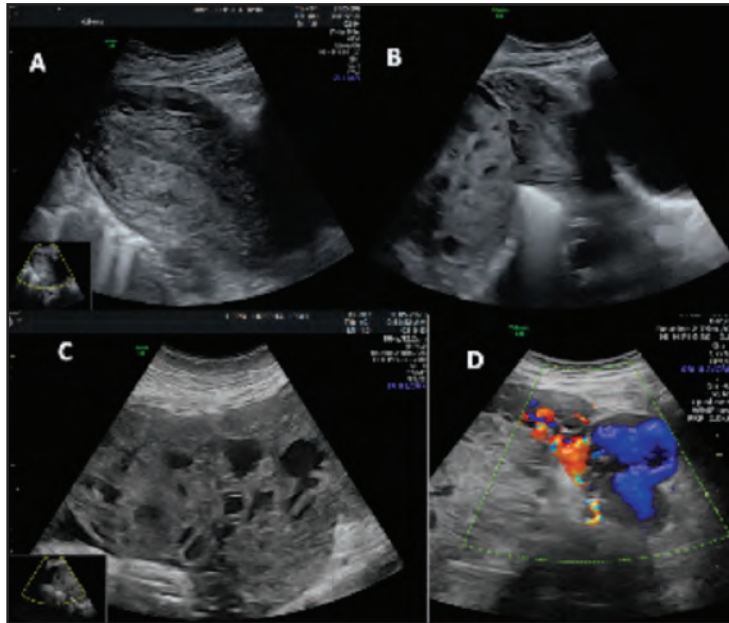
Ultrasound images (A) Empty uterus; (B) Placental attachment to right posterolateral uterine wall; (C) Loss of intervening myometrium between placenta and anterior abdominal wall; (D) Adnexal vessel plexus with doppler enhancement.
